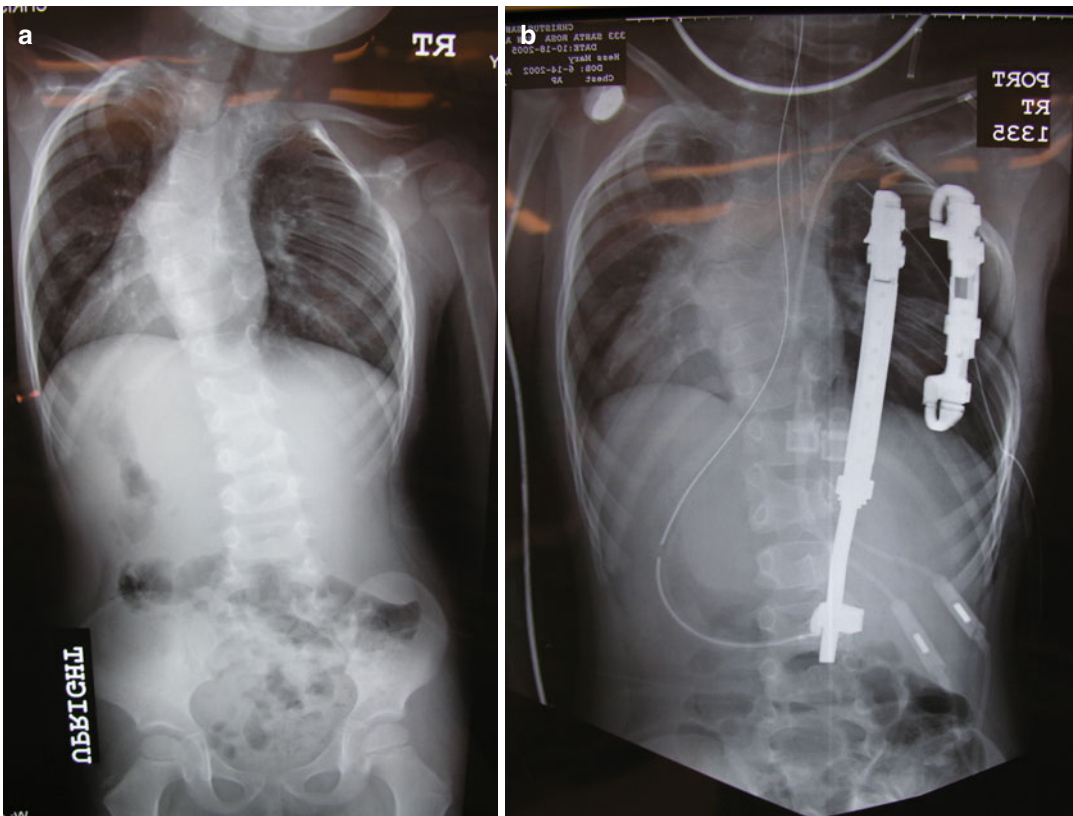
(a) Preoperative x-rays of a rib fusion and congenital scoliosis patient. (b) Postoperative x-rays of a rib fusion VEPTR procedure
